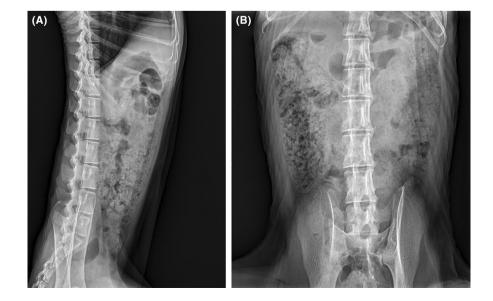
Abdominal radiographic exploration. 2 weeks after the initial exploration. (A) Lateral view and (B) ventrodorsal view. Note the presence of severe constipation and the palpable consolidation in the right lateral abdomen.
